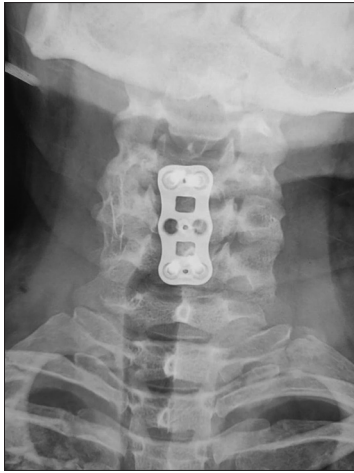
Postoperative plain anteroposterior radiograph demonstrating C5 corpectomy, bone grafting, and anterior cervical plating
